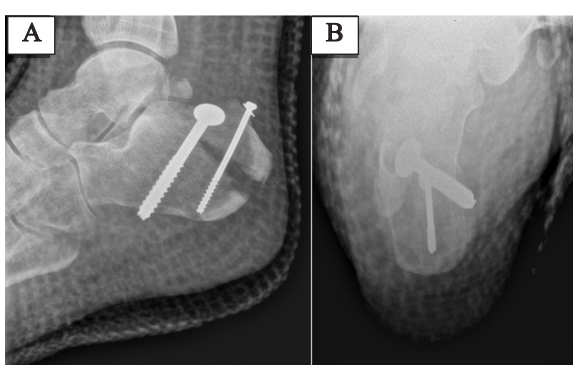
Radiographs at four-week follow-up. (A) Lateral and (B) axial views demonstrating recurrent displacement of the tongue-type calcaneal fracture and hardware migration.
